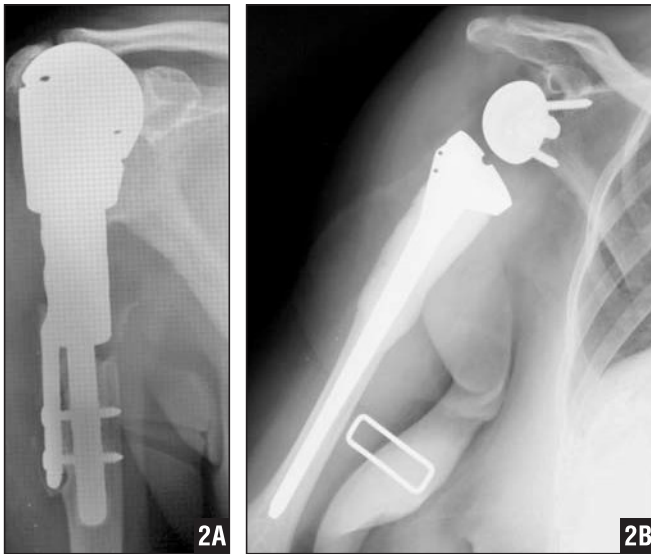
Dislocated special implant after giant-cell tumor resection of the humeral head with pain at rest (A). Postoperative radiograph (B).
